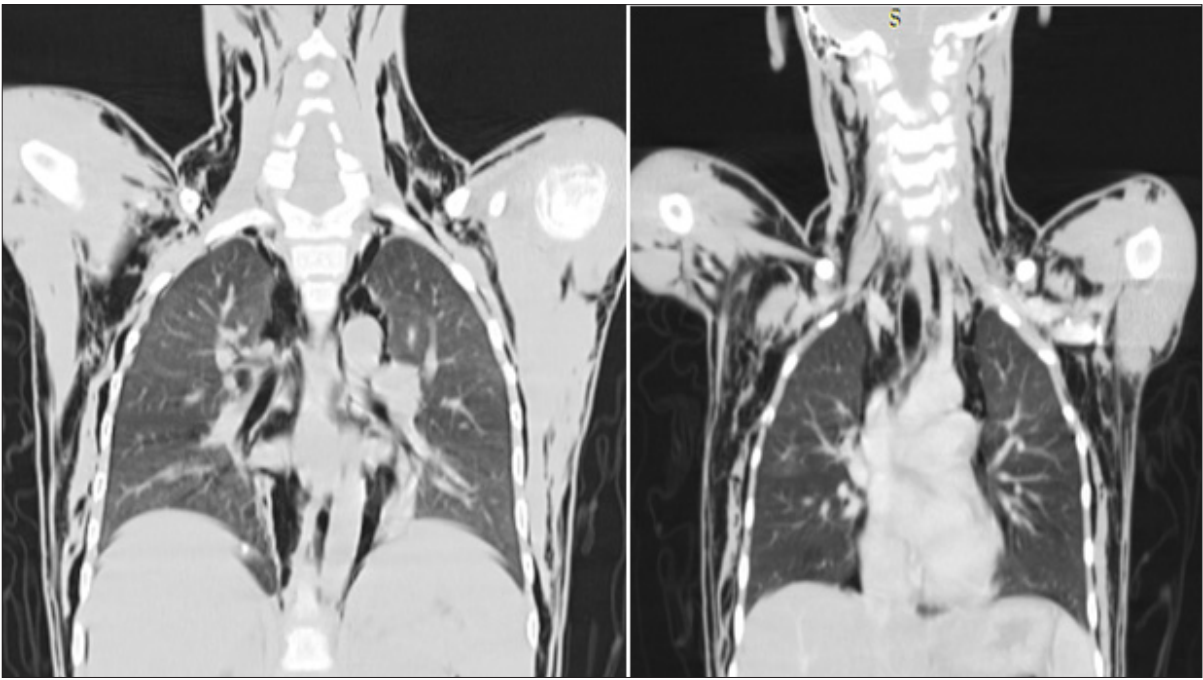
coronal sections of chest CT-scan shows air in mediastinum compartments and subcutaneous tissue of Thorax and Neck
